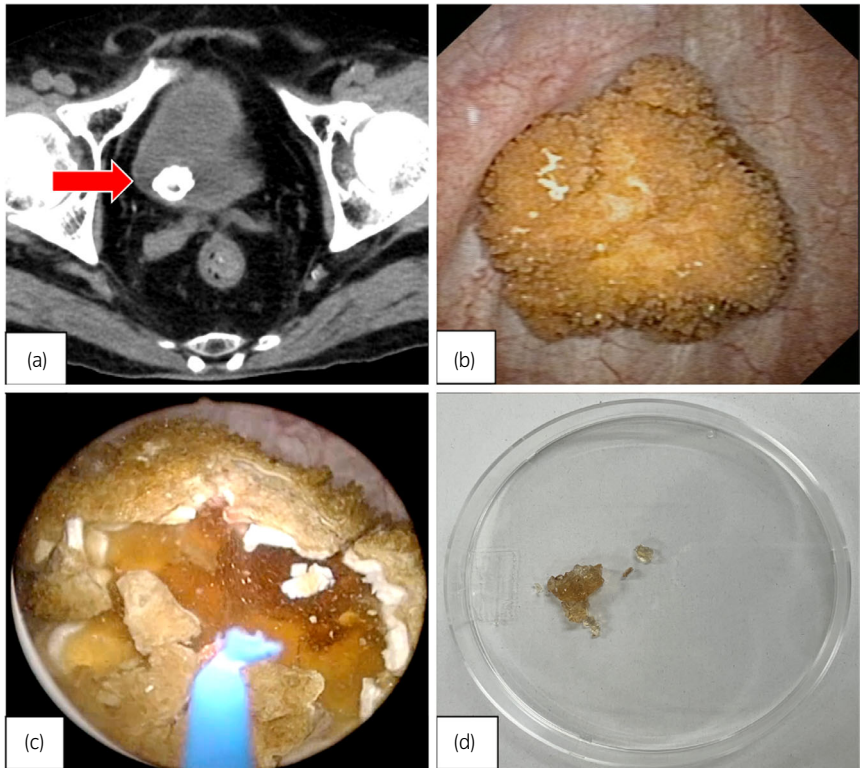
(a, b) A CT scan performed 6 months after inserting the hydrogel and a cystoscopy scan show a bladder stone of $1.5 \times 1.5 \times 1.1$ cm. The average CT HU was 308 HU. (c, d) Transurethral lithotripsy by holmium laser revealed the hydrogel inside the stone.
